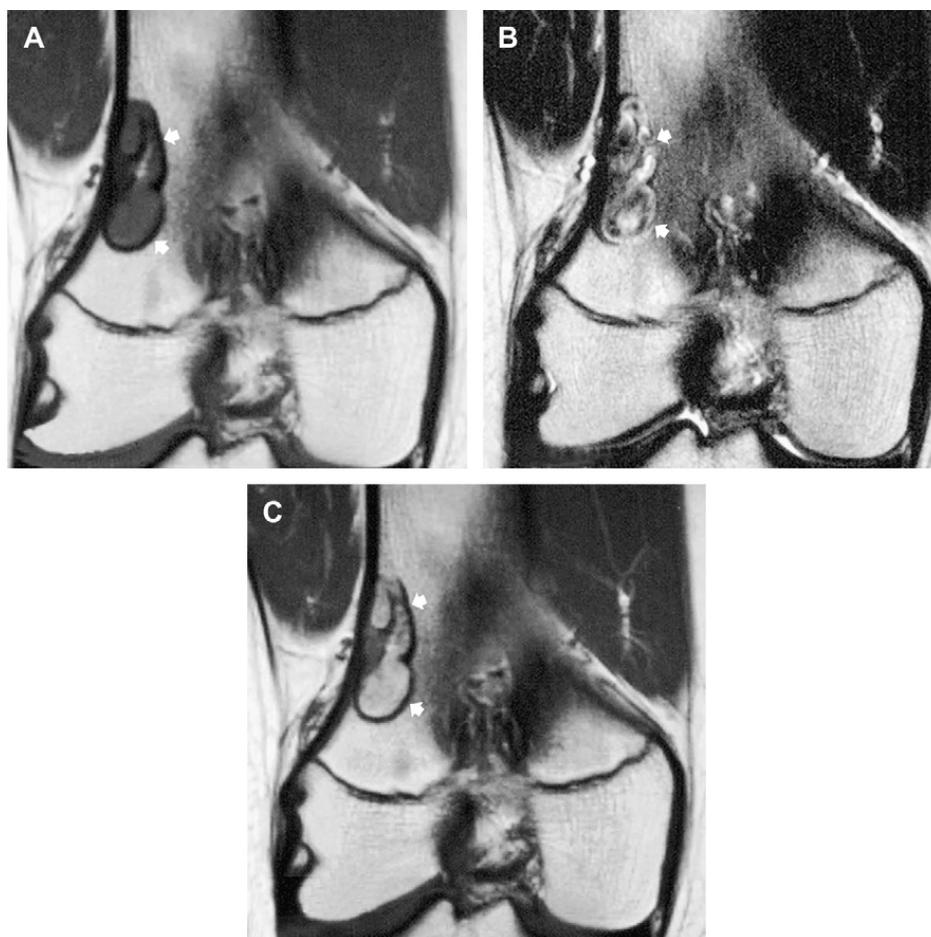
Fibroxanthoma (nonossifying fibroma) in the distal femur of an adolescent boy. (A, B) Corresponding coronal T1-weighted (TR/TE; 450/12) spin-echo MR images preceding (A) and following (B) the administration of intravenous contrast show marked, relatively intense enhancement (arrows). Note typical eccentric metaphyseal location and lobulated contour. (C) Corresponding turbo T2-weighted (TR/TE; 4000/96) spin-echo MR image shows a heterogeneous low-to-intermediate signal intensity.
